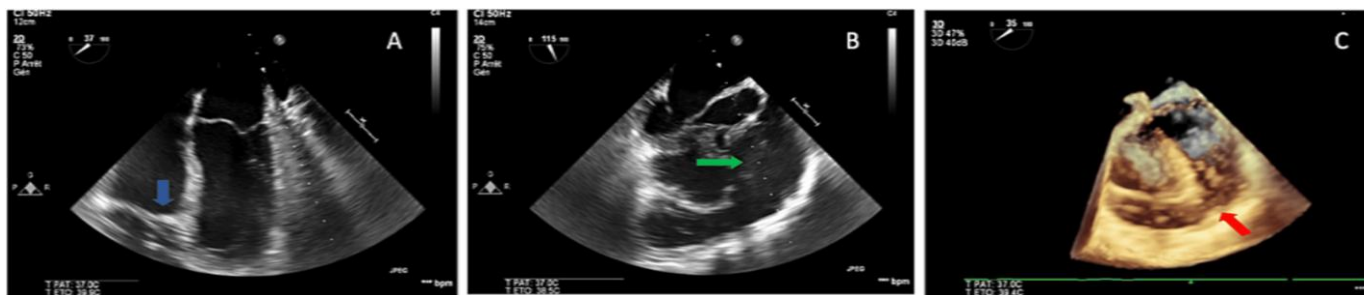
Figure 1: (1A) 2D Transoesophageal Echocardiography (TOE) image showing displacement of the septal leaflet (blue arrow) towards the apical right ventricle, (1B) 2D TOE image showing dilated right ventricular outflow (green arrow) , (1C) 3D TOE image showing tunnel- shaped apical portion of the right ventricle (red arrow)
